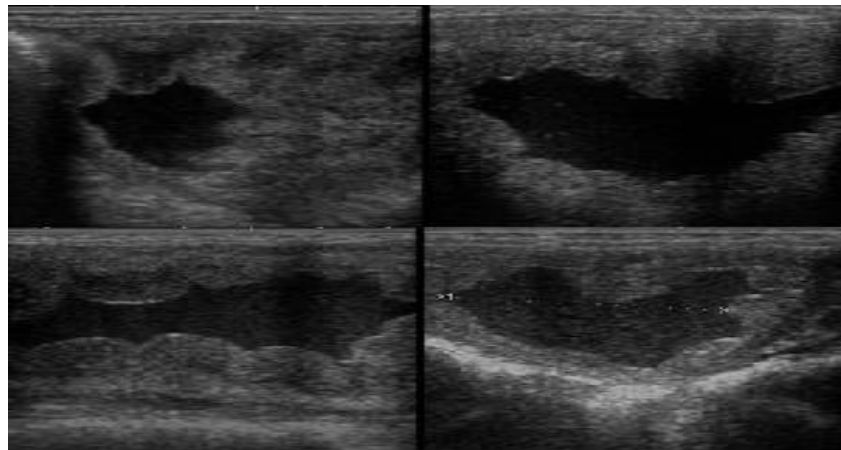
Ultrasound images of pathological intrauterine fluid accumulation exceeding 2cm in various mares.
